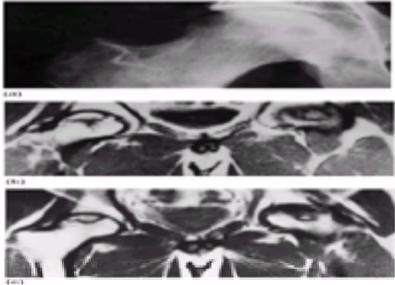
(a) Early changes of osteonecrosis of the femoral head shown on plain radiograph (Arlet and Ficat stage II). (b) MRI clearly detects osteonecrosis at an early stage in T_1 -weighted and (c) T_2 -weighted images. (By courtesy of Dr P. Renton, University College London.)
